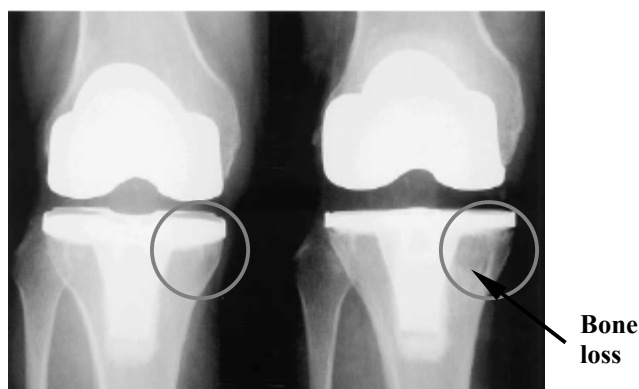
Radiographs immediately after a primary knee arthroplasty and at 4 years after surgery show the bone loss in the medial tibial plateau that was not present initially or at the 1-year follow-up (Callaghan *et al.* 2004).
